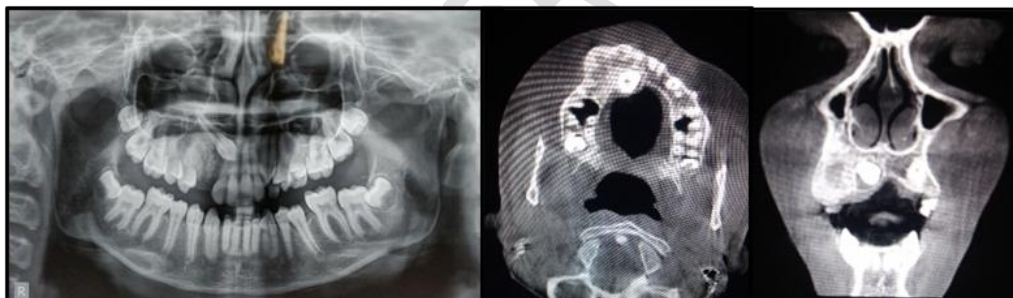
OPG and CBCT showing a well defined multilocular radiolucency surrounding 13 , extending from the midline to 14 region causing cortical expansion as well as root resorption of 53
